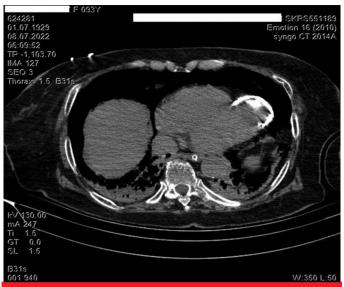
Thorax computed tomography: A round, calcified, and cystic structure in the apical wall of the left ventricle and a thrombus in this structure.
